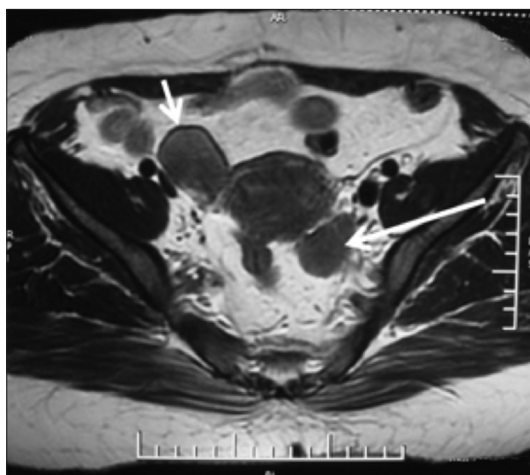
T2 Weighted magnetic resonance imaging of pelvis showing bilateral ovarian masses, which are homogeneous and mildly hyperintense (arrows). There are no follicles seen in bilateral ovaries
